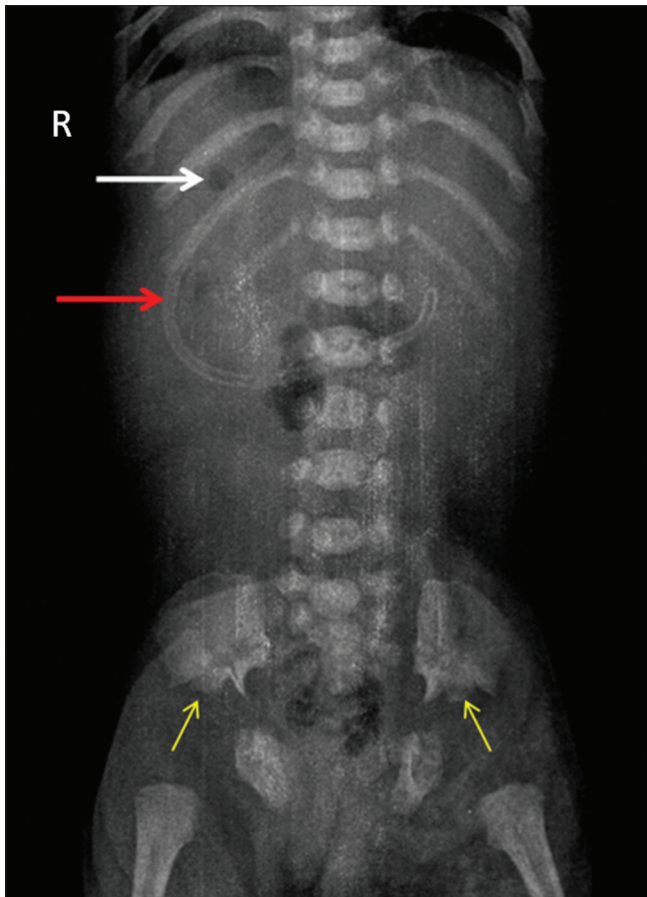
Plain radiograph of the abdomen shows gastric air lucency on the right side of the abdomen (*white arrow*) and the nasogastric tube (*red arrow*) curving along the right side of the abdomen indicating a situs disorder. Short iliac wings with sharp sacro-sciatic notches and “trident” appearance of acetabulae (*yellow arrows*) are seen. There is paucity of large bowel loops in their normal peripheral location
